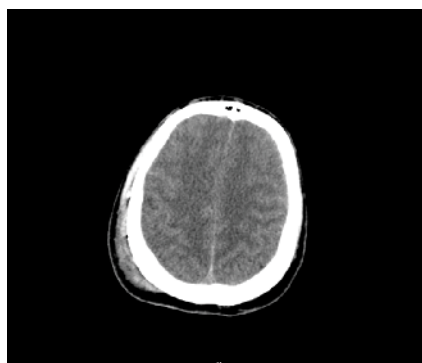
CT showing diffuse cerebral edema.
